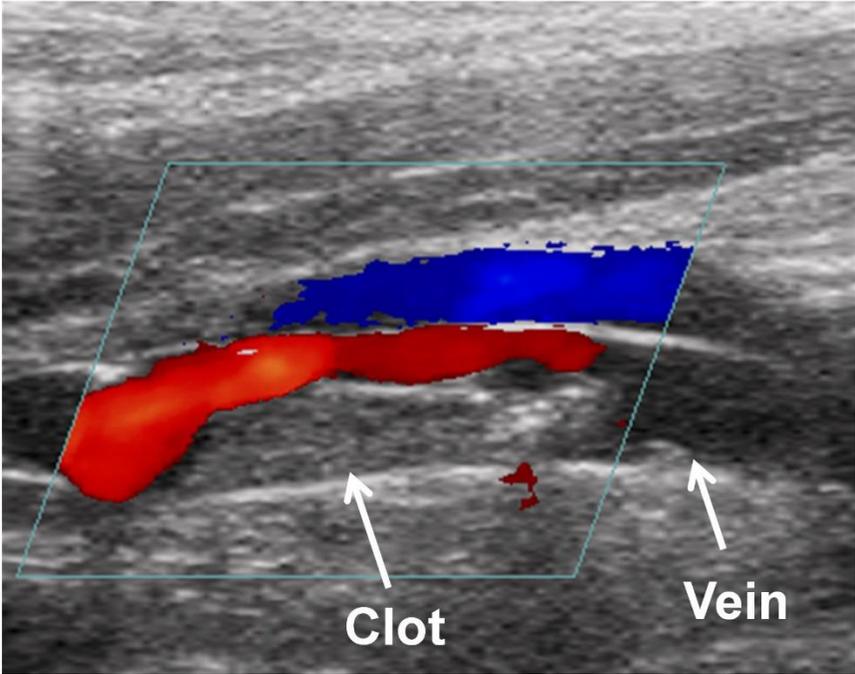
Doppler of Thrombosed Vein
